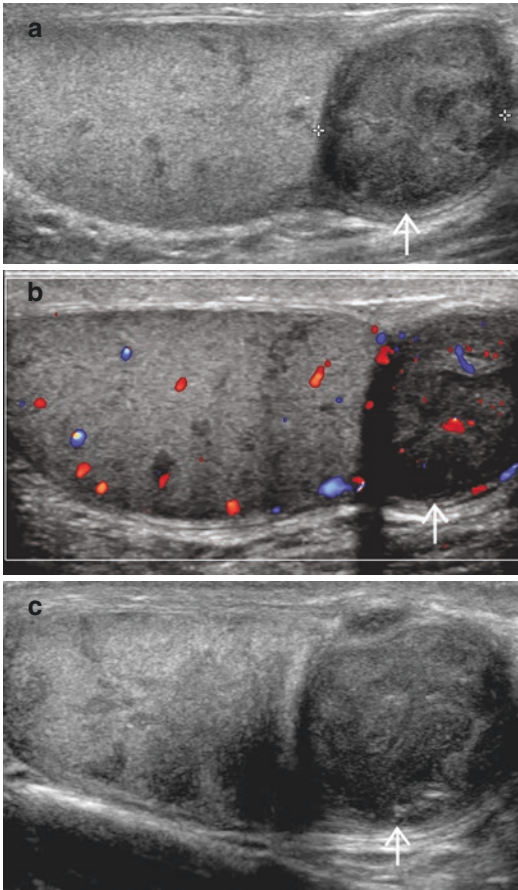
Bilateral tuberculous epididymo-orchitis. Longitudinal (a) gray-scale and (b) color Doppler US images of the left hemiscrotum show an enlarged heterogeneously hypoechoic epididymis (arrow) with concomitant multiple small hypoechoic nodules in the testis, compatible with a miliary pattern. Increased vascular flow in epididymis and testis is also seen. (c) Longitudinal US image of the right hemiscrotum shows an enlarged heterogeneously hypoechoic epididymis (arrow) and testis
